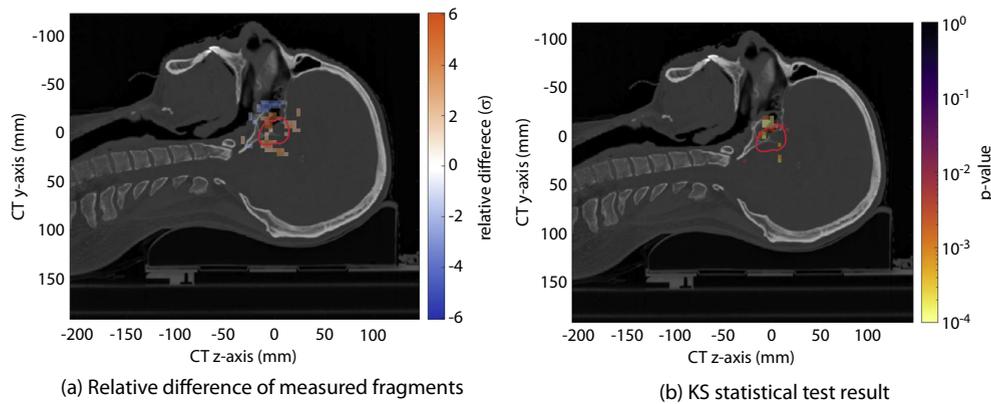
Comparison of the measured fragment distributions in the sagittal plane. The red line delineates the planning target volume. (a) Relative difference of the measured fragment distributions. (b) Two-sample KS statistical test result of the measured fragment distributions. *Abbreviation:* CT = computed tomography; KS = Kolmogorov-Smirnov.
